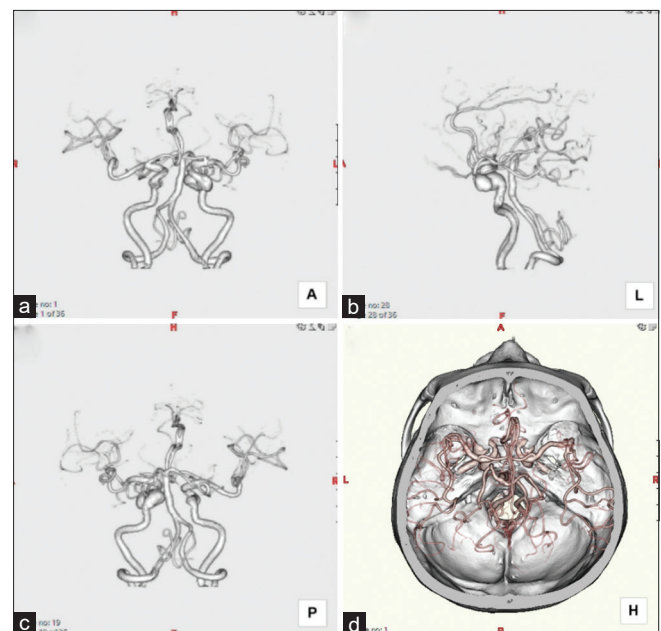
Preoperative three-dimensional computed tomography angiogram of the left internal carotid artery with cavernous carotid aneurysms (a: Anterior view; b: Left lateral view; c: Posterior view; d: Head view with bone window)
